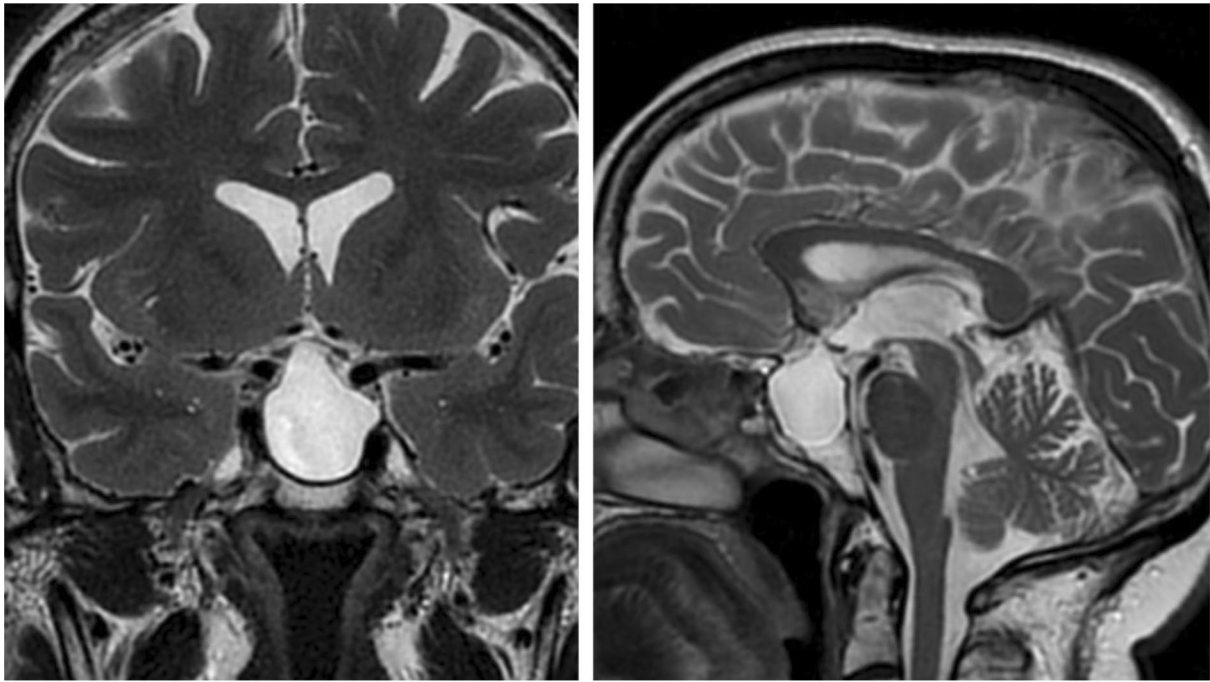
3-month postop MRI-scan with cyst reacumulation and fat graft shrinkage
